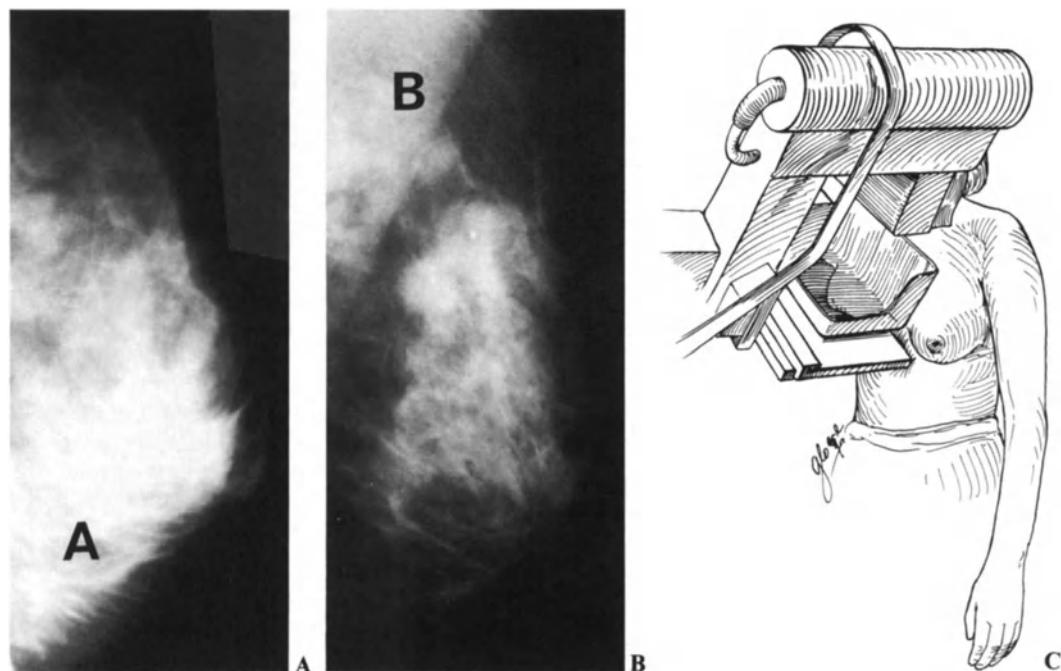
The necessity for dedicated mammography equipment. A A mammogram made with general diagnostic X-ray equipment and inadequate compression. There is a hint of some skin changes medially but the stellate cancer that is obvious in B is not evident and was missed. B The same breast imaged with dedicated mammography equipment without a grid readily demonstrates the cancer and skin changes.
